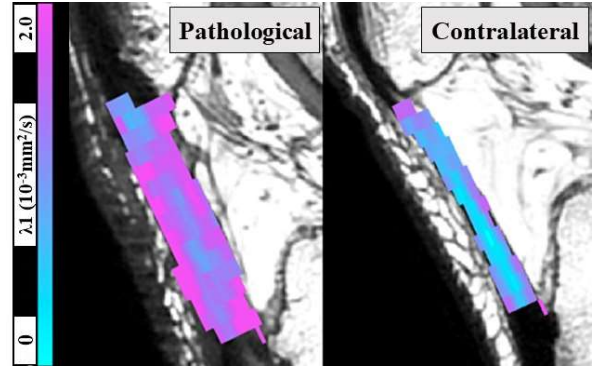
Diffusion scalar map of λ_1 overlaid on proton density MRI from a participant 8-months after BPTB autograft harvest.
